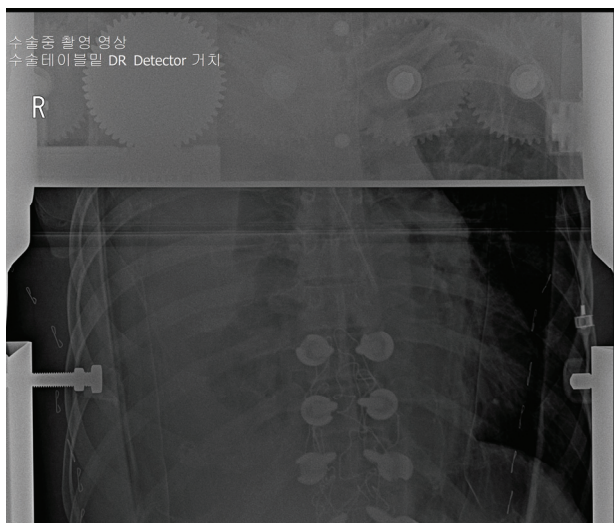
Intraoperative chest radiograph (PA view, prone position) showing massive hemothorax in the right lung field.
